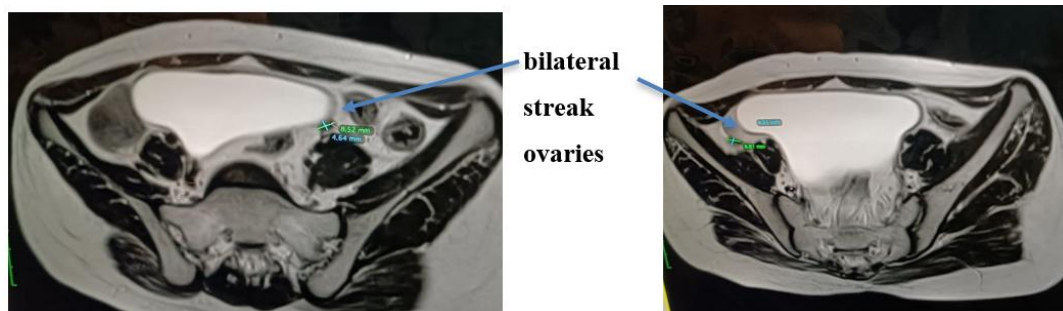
and Fig-7 MRI PELVIS- bilateral streak ovaries right ovary measuring 8.8x4.4mm and left ovary measuring 8.5x4.6mm with no evidence of follicles.
